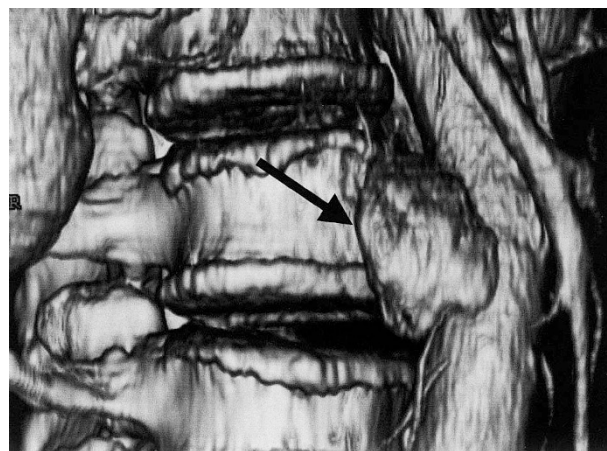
Enhanced CT revealed a slightly enhanced para-aortic tumor in the lower duodenum.
